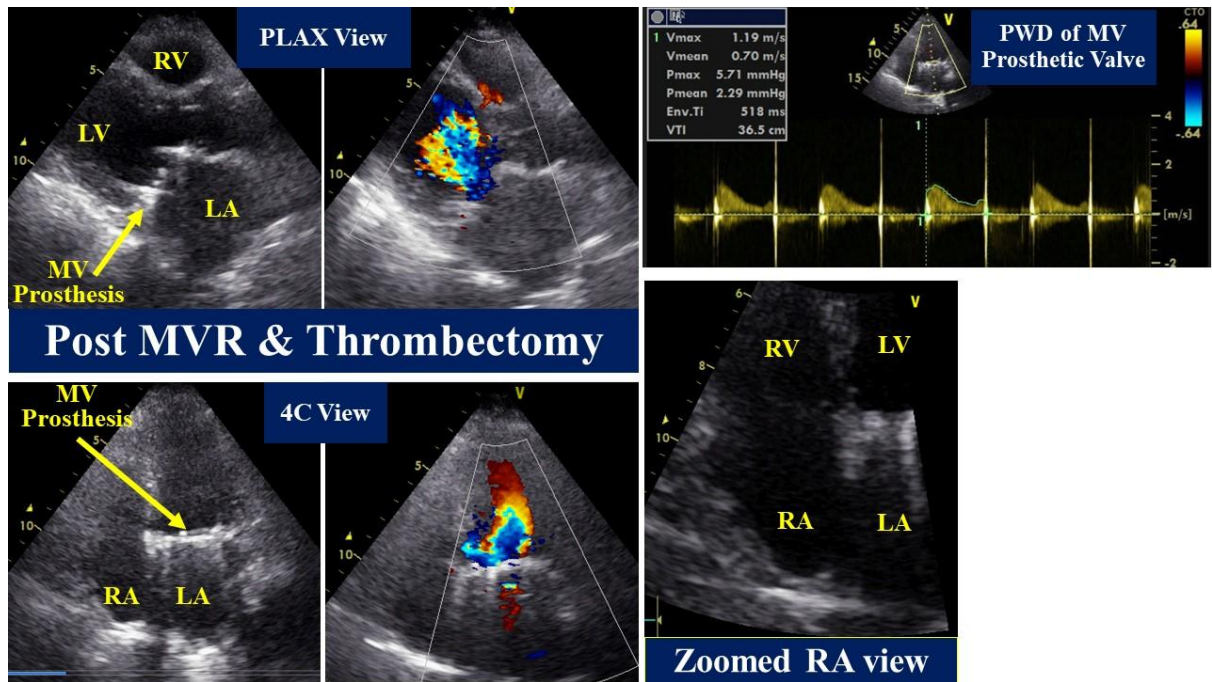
Post Procedural 2D Echocardiographic Stills
